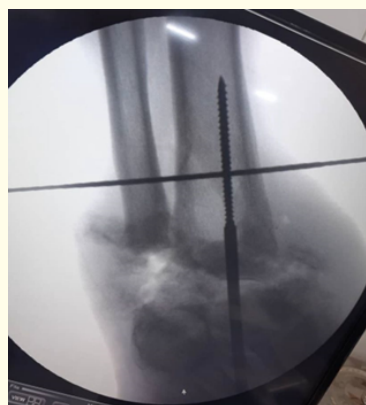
Fluoroscopy Radiograph AP showing postoperative arthrodesis of ankle joint using Ilizarov.
